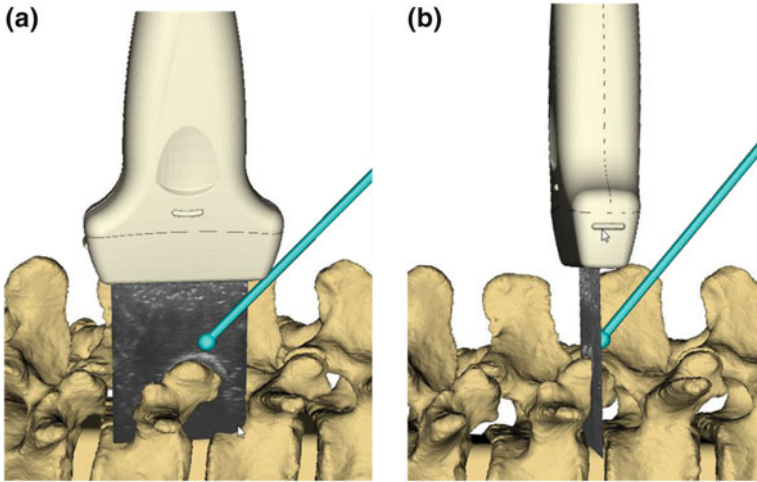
In-plane and out-of-plane techniques in ultrasound-guided needle insertions
